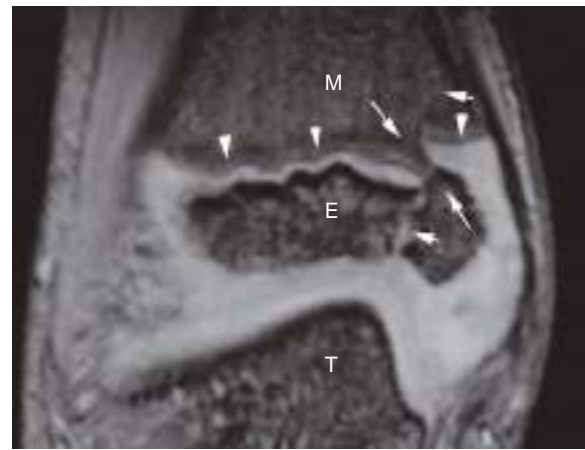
Physeal bar and deformity after distal tibial physeal injury. Coronal fat-suppressed spoiled gradient-echo MR image shows the bony bridge (long arrows), old Salter–Harris IV fracture line (short arrows), and the physis (arrowheads). Note the angular deformity between the talar dome (T) and distal tibial epiphysis (E). M, metaphysis.
